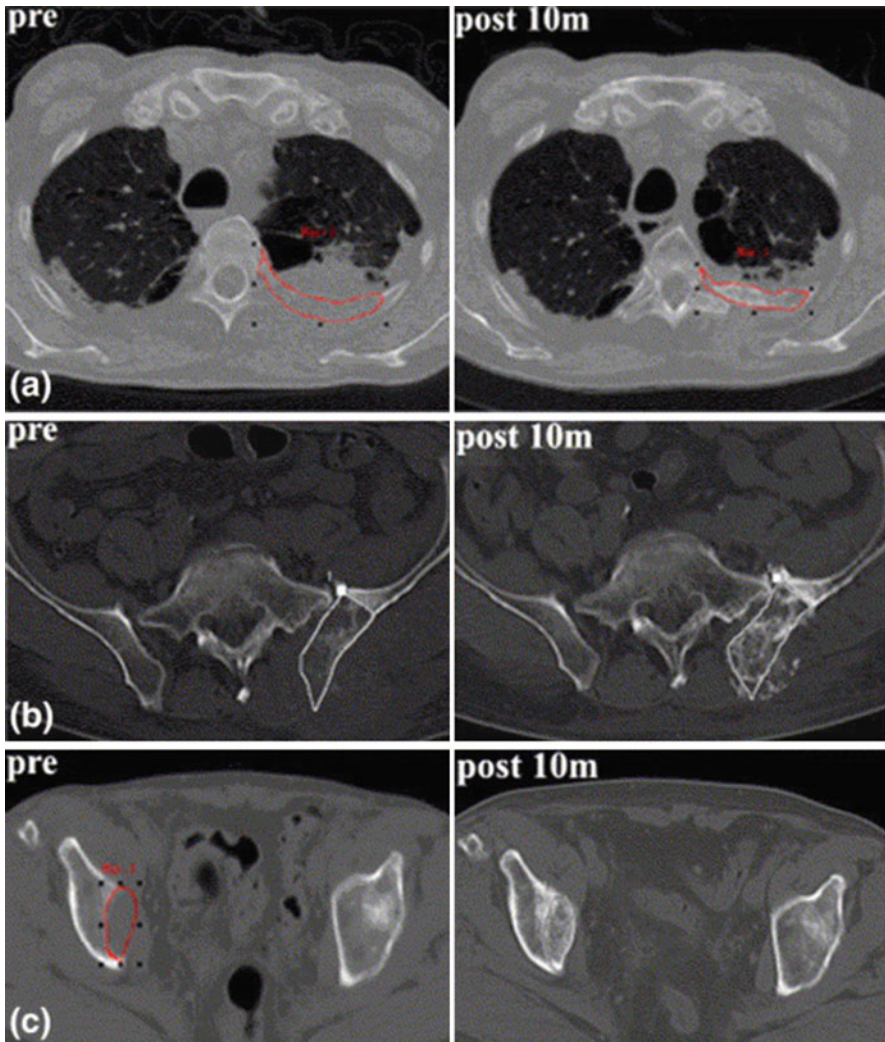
CT images of patients with lytic bone metastases before and 10 months after the onset of concurrent application of RT and Bps in a patient with (a) lung carcinoma and two different patients with renal carcinoma (b, c) showing significant reossification in an upper left rib, left iliac bone and right iliac bone respectively (This figure is reprinted from the International Journal of Radiation Oncology Biology Physics 2007;67:264–272, figure 6, copyright 2007, after a kind permission of Elsevier Inc)
